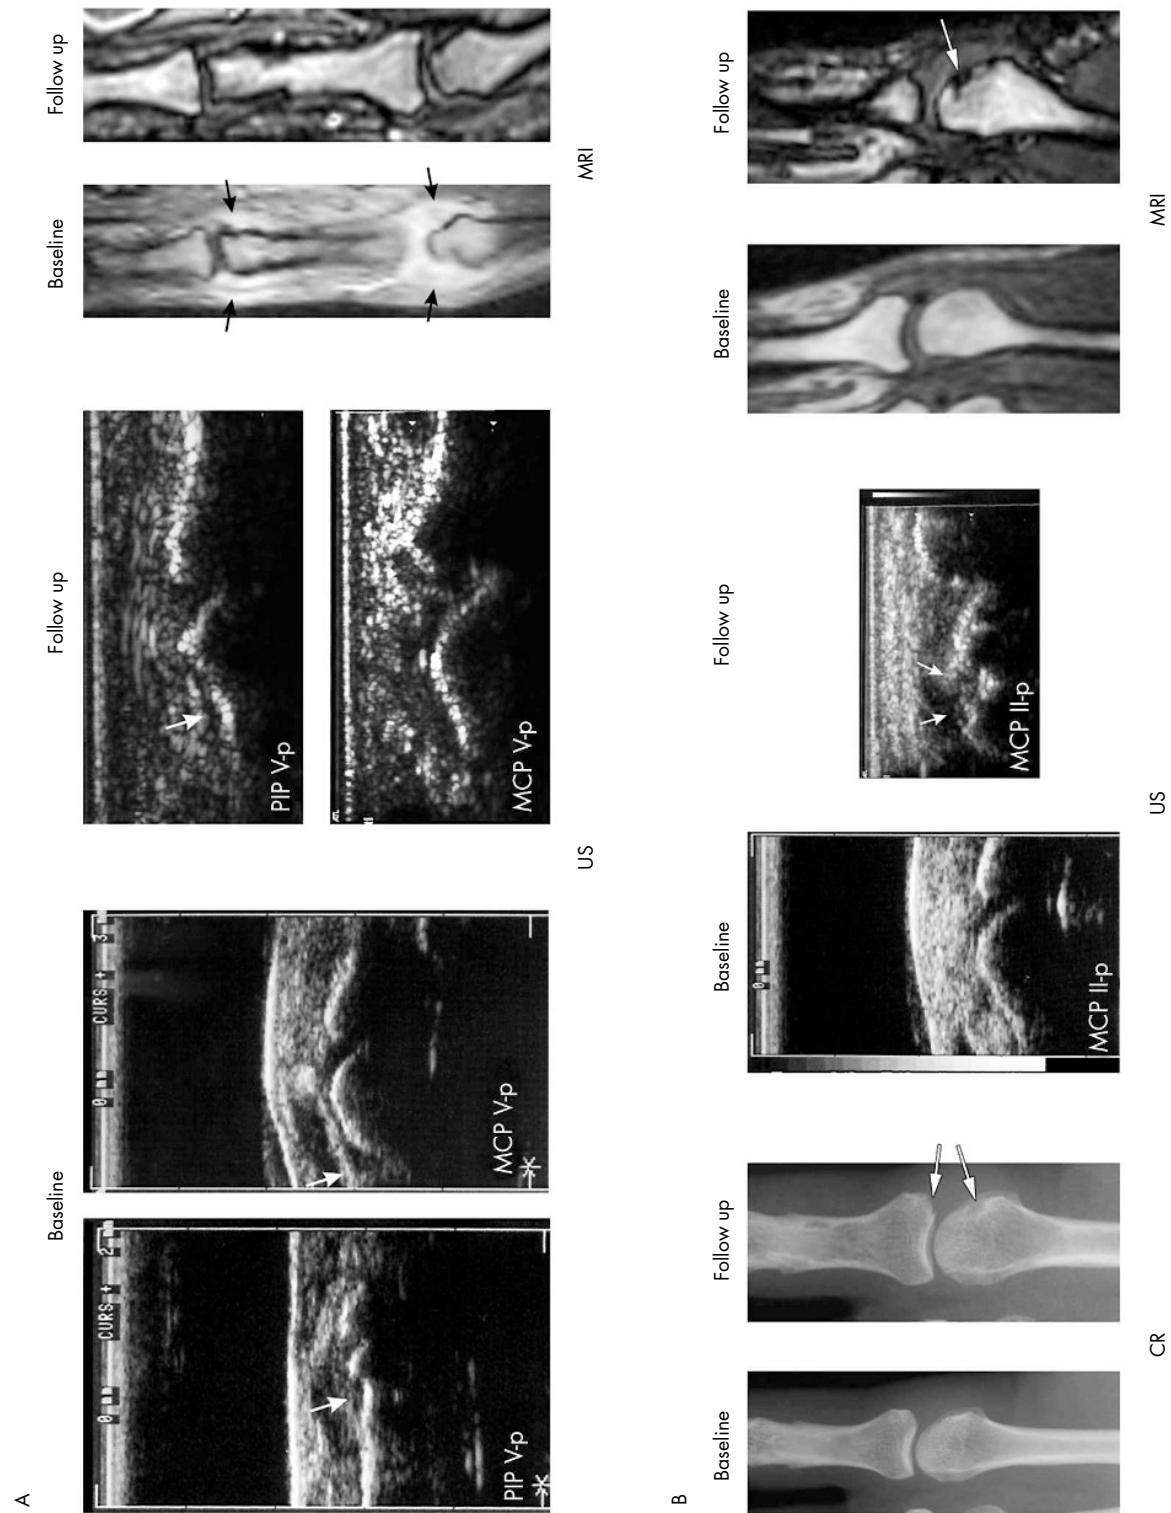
(A) MRI and US show marked synovitis at MCP and PIP joints V at baseline (arrows). At follow up after 7 years no synovitis is present at MCP and PIP joints V with MRI, whereas minimal synovitis can be seen at PIP joint V with US. (B) Images of the same MCP II joint at baseline and follow up visit with three different imaging techniques. In radiography, there is no erosion at baseline, while there is an irregularity at the 7 year follow up (arrows). In US and MRI there are no erosions detectable at baseline, while there are clear erosions at the follow up visit.
